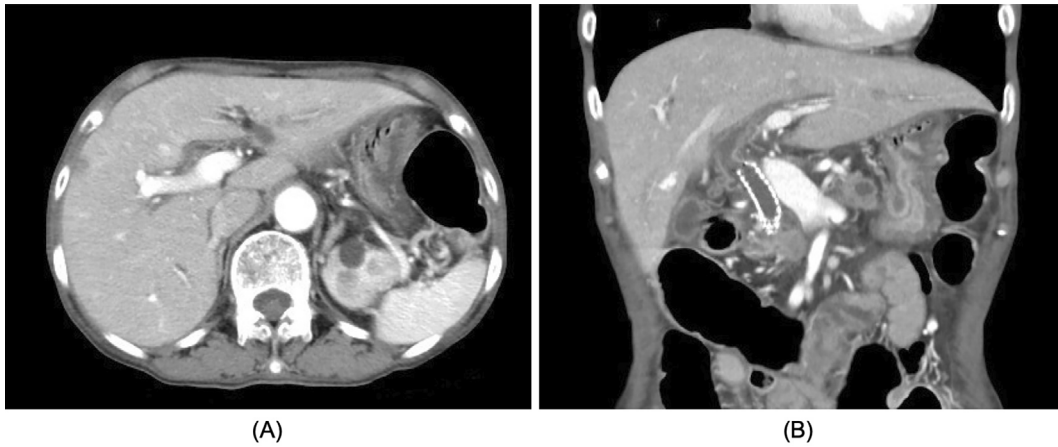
Abdominal contrast-enhanced computed tomography scans obtained at the onset of acute cholangitis. (A) Intrahepatic bile ducts are dilated. (B) The fully covered self-expandable metal stent is not obstructed and is appropriately positioned in the common bile duct. There was no wall thickening of the gallbladder or enlargement of the gallbladder.
